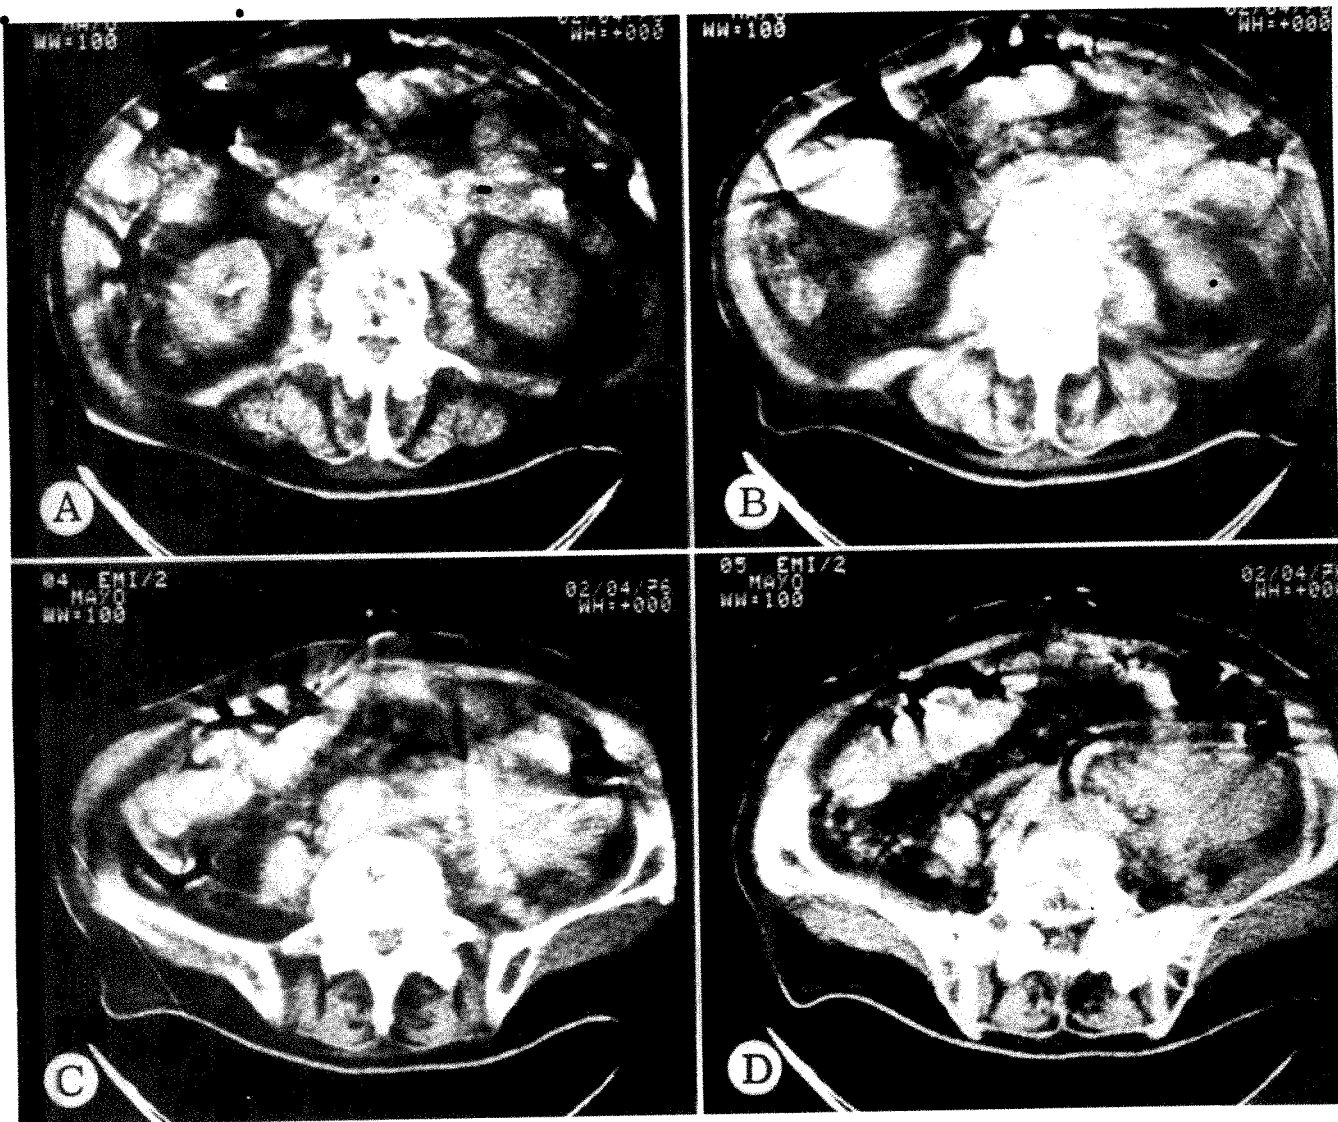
CT scans of 91-year-old man with severe, unrelenting back pain and tenderness over L4 vertebral body. Clinical suspicion was epidural abscess. Poorly circumscribed infiltrating mass seen adjacent to lower abdominal aorta (A and B) appearing to infiltrate or be adherent to several loops of bowel (C and D). At operation, malignant lymphoma extended from left kidney down over aorta and adjacent to left iliac artery. Portions of mass infiltrated mesocolon.
